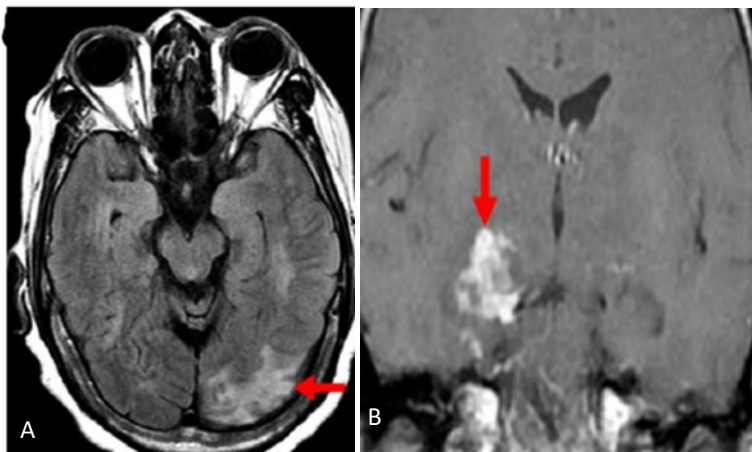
A: T2/FLAIR; MRI of definite NS demonstrates T2 hyperintensity in the occipital lobe (arrow).
